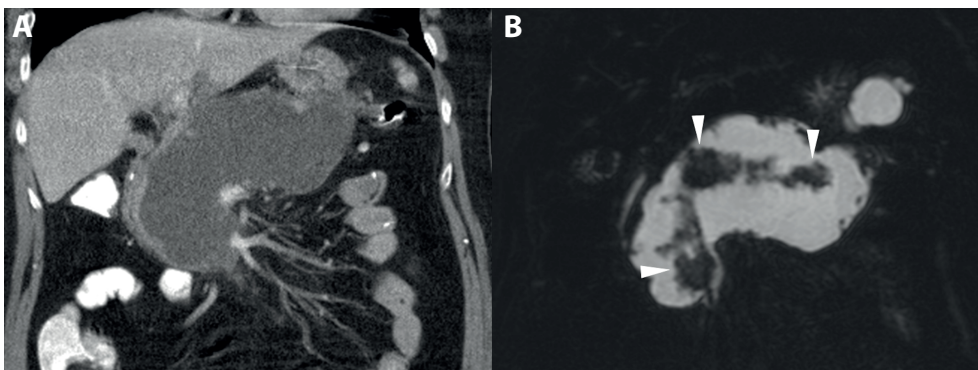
CT versus MRI of walled-off necrosis. (A) CT shows walled-off necrosis replacing a large part of the pancreatic parenchyma. (B) Corresponding T2-weighted MRI accurately depicts necrotic material (arrowheads) within the collection.
